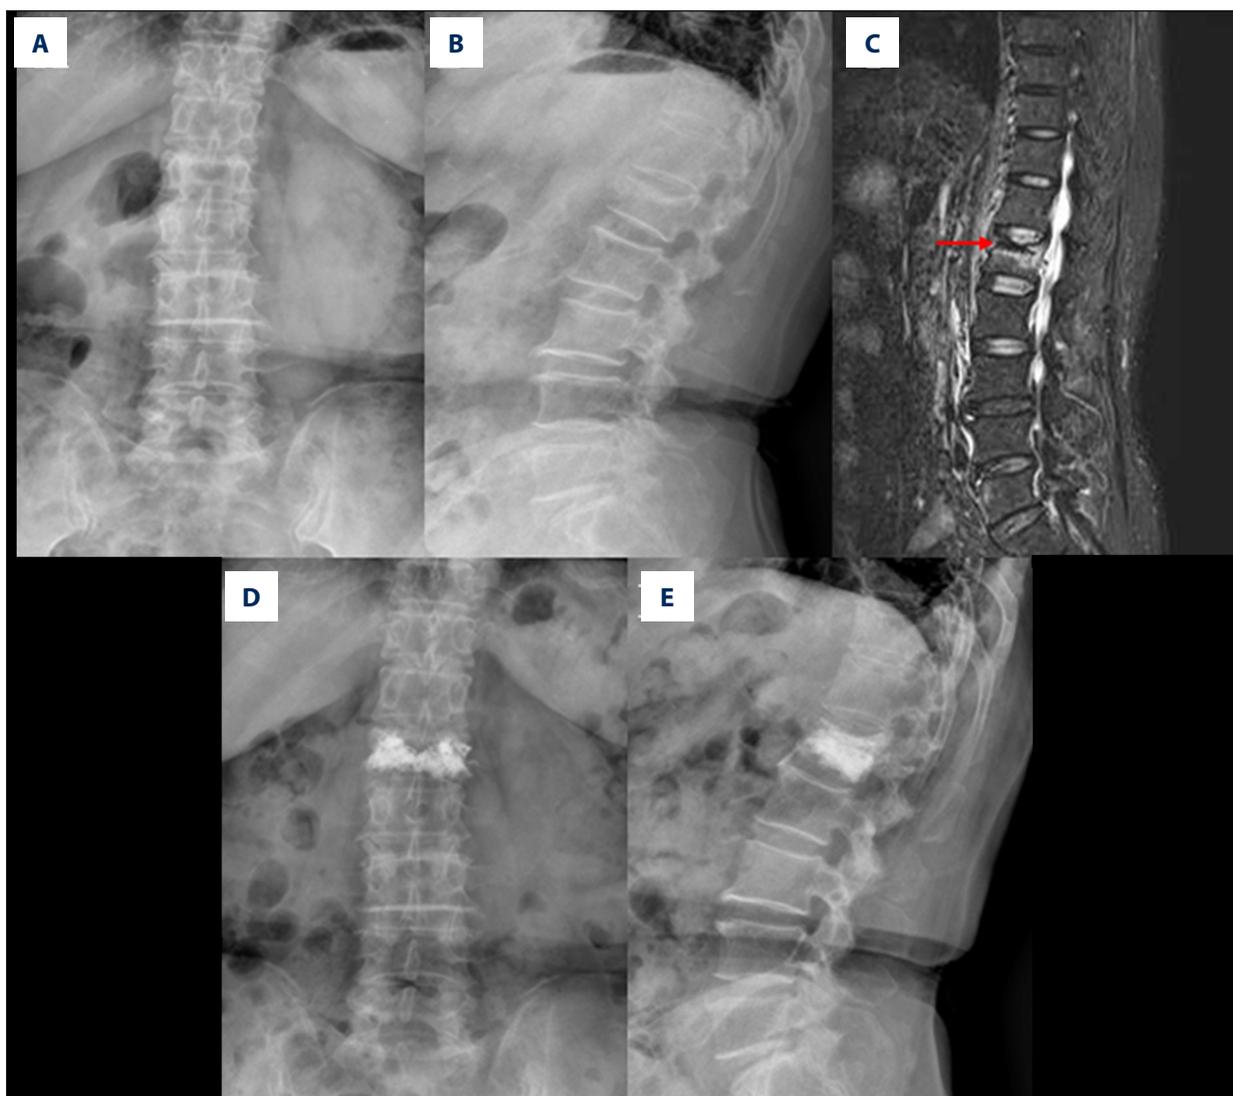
A 67-year-old female patient had a L1 osteoporotic vertebral compression fracture as a result of a fall. (A, B) X ray showed L1 vertebral compression fracture. (C) A linear black signal was detected on MRI STIR sequence (red arrow). (D, E) At one-year follow-up, bone-union was achieved after PKP. Anteroposterior and lateral radiographs showed no decrease in anterior vertebral height and no increase in kyphosis angle after a follow-up of one year.
